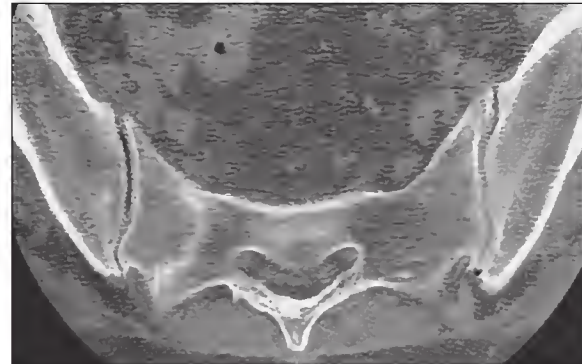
Fracture. Computed tomography of the sacral spine demonstrates a sacral fracture not visualized with plain radiographs.
